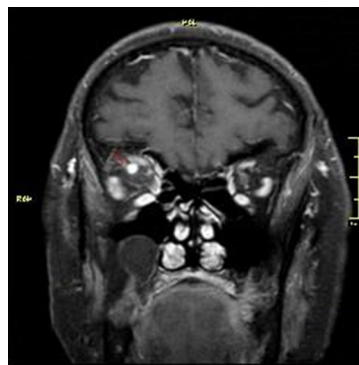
Prominent superior ophthalmic vein observed in orbital MRI.
